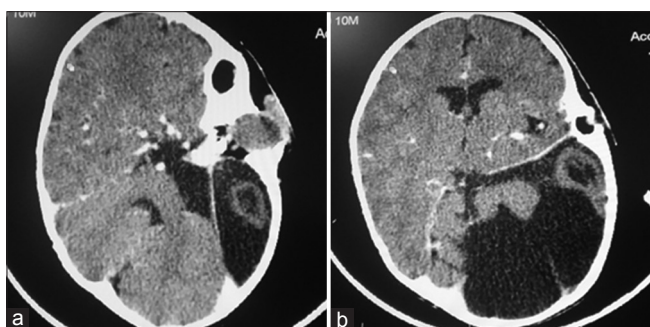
Axial computed tomography scan brain window showing (a) duplicated globe within the left temporal bony orbit (arrow), (b) a large arachnoid cyst in the posterior fossa (crossed arrows)
